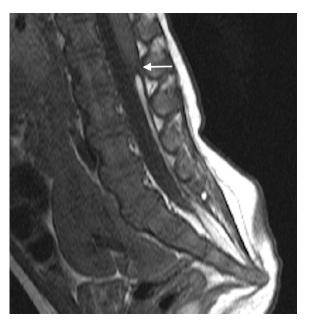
Sagittal T1 MRI shows abnormal T1 hyperintensity of the filum compatible with a filar lipoma. The conus terminates at L2 (white arrow). It is postulated that early errors during gastrulation may progress to involve primary and secondary neurulation, which may explain the presence of a filar lipoma in this case.
